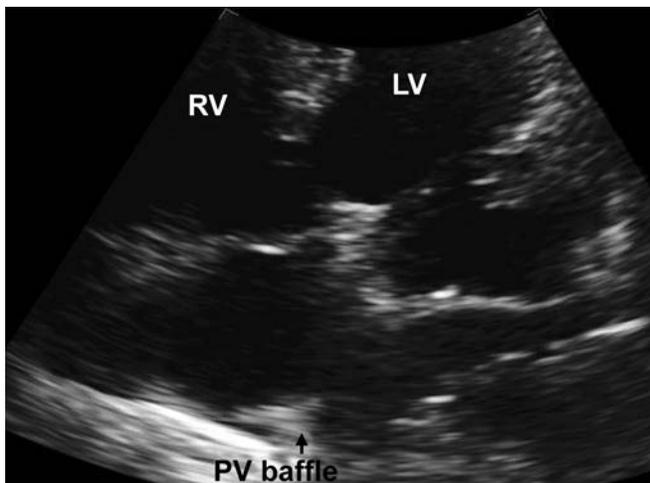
Transthoracic 4-chamber view with focus on the tricuspid valve.
